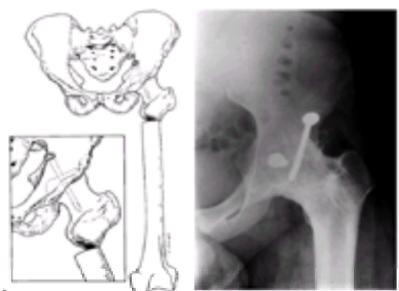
A: Hip arthrodesis is performed through an anterior approach. The abductor muscles are not disturbed. Compression arthrodesis is achieved with minimal hardware. A proximal femoral osteotomy reduces force on the fusion area, and allows for adjustment in limb position postoperatively. (From ref. 177, with permission.) B: Anteroposterior hip radiograph of a 16-year, 4-month-old boy demonstrates a solid hip arthrodesis performed by the previously described technique. Femoral head osteonecrosis had occurred following treatment for slipped capital femoral epiphysis.
